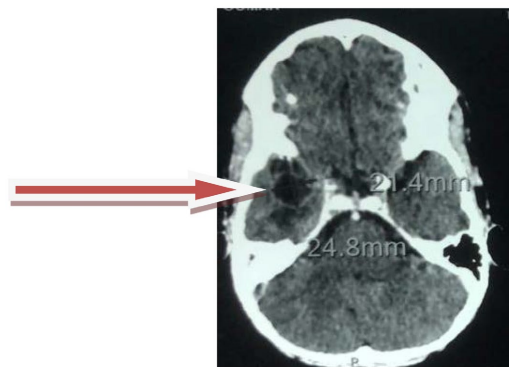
Axial CT scan showing the right temporal collection.
